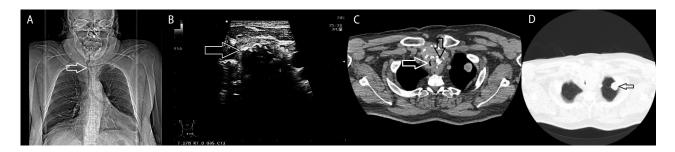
Imaging studies. A. Chest X-ray showing the compressed trachea (arrow); B. Ultrasound scan of the left lobe of thyroid gland showing massive calcifications (arrow) within thyroid tissue; C. Computed tomography of the neck and chest showing goitre with massive calcifications within thyroid tissue (black arrow) and compressed trachea (white arrow); D. Computed tomography of the neck and chest showing the lung tumour as a manifestation of the IgG4-related respiratory disease
